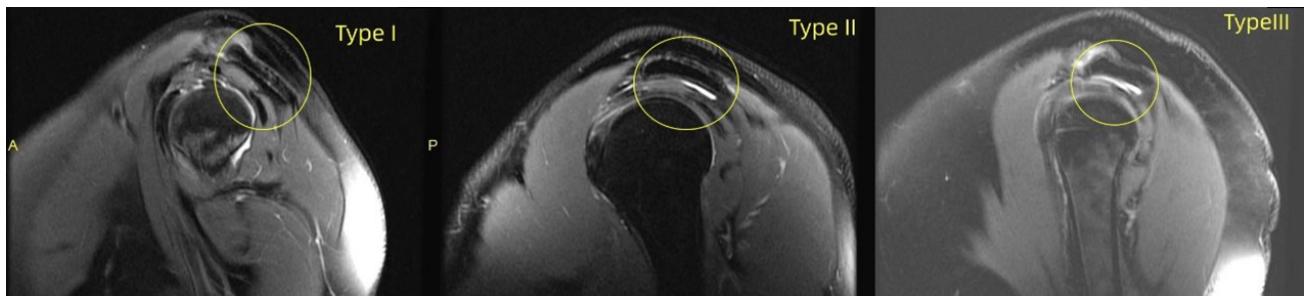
Three typical acromion shapes observed on Magnetic Resonance Imaging (MRI). Each of the three acromion forms is shown in the yellow circle.
